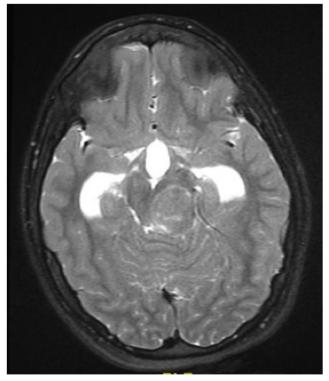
A 13-year-old girl with a midbrain mass. Axial T2-weighted image. Underwent an ETV and followed for 7 years. The tumor mildly grew and was never treated
